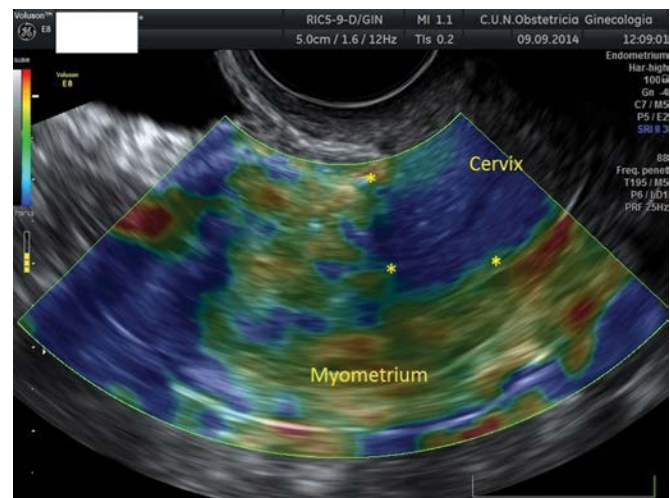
Transvaginal ultrasound elastography showing the cervical tumor (*) colored as dark blue (high strain ratio).
